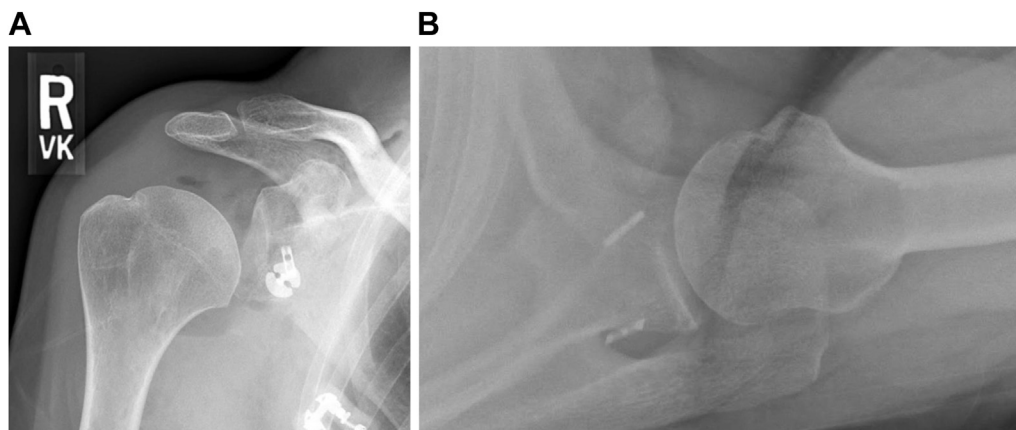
(A and B), Anteroposterior (A) and axillary (B) radiograph demonstrating the suture button construct used for fixation of the coracoid during the Latarjet procedure.
